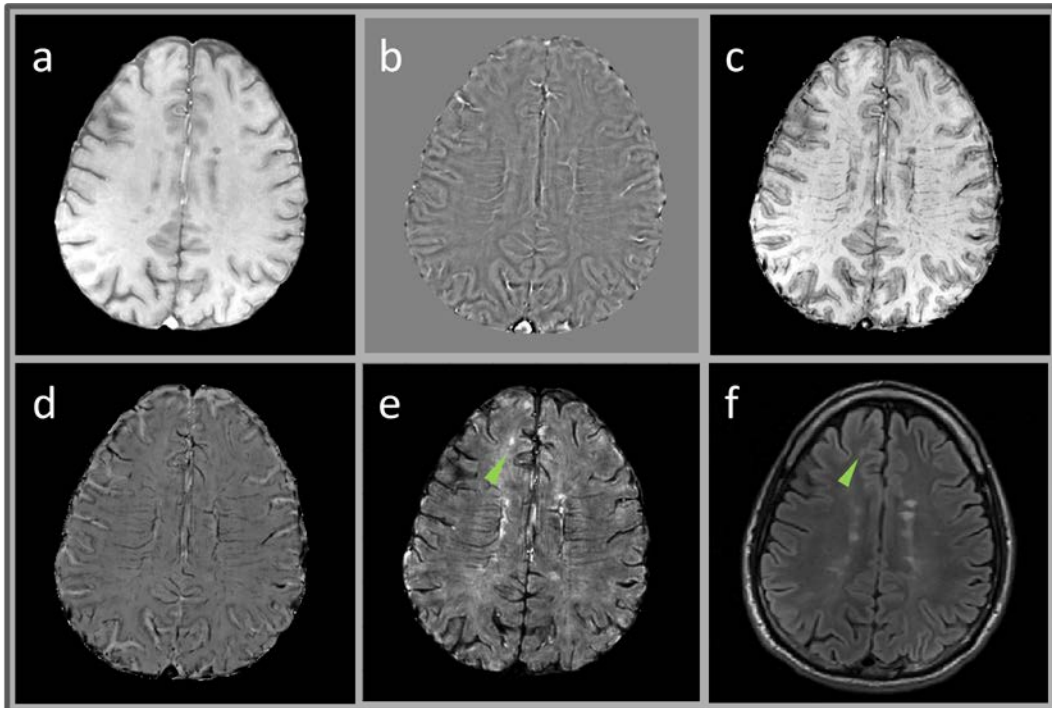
Examples of a series of GEPCI images applied to disease of Multiple Sclerosis. a) GEPCI-T1weighted image; b) frequency map; c) GEPCI-T1f image; d) GEPCI-SWI image; e) T2*-SWI, result from d multiplied by FST2* image; f) FLAIR image. Most MS lesions (hyperintense on e and f) are seen around veins; green arrow indicates example of lesion that is not affiliated with identifiable blood vessels.
